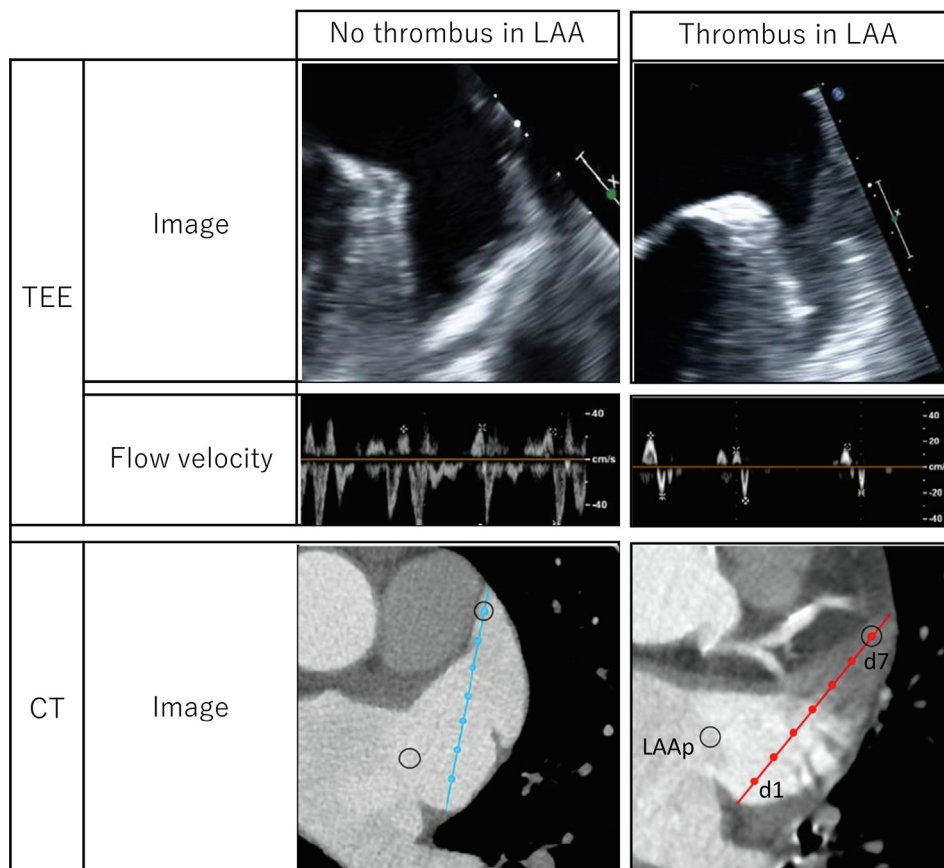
Representative examples of presence and absence of LAA thrombus as observed by TEE and CT. A thrombus was defined as a well-contoured homogeneous echogenic mass within the LAA cavity by TEE (upper row). The patient with an LAA thrombus had a lower LAA blood flow velocity than the patient without an LAA thrombus (middle row). Cardiac CT of patients with an LAA thrombus showed a contrast-enhanced defect in the distal part of the LAA (lower row). The HU density was evaluated in a horizontal section with maximum depiction of the LAA cavity. Eight distinct points were determined at one proximal and seven distal sites of the LAA (LAAp and LAA1–7, respectively). CT indicates computed tomography; HU, Hounsfield unit; LAA, left atrial appendage; TEE, transesophageal echocardiogram.
